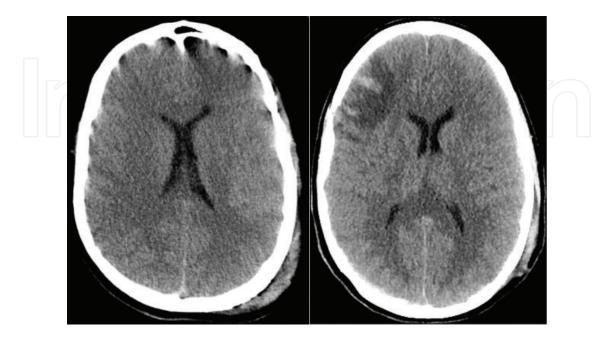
Computed topography scan of patient diagnosed with DAI [42]. From left to right, CT scan of day 1 vs. 11.
